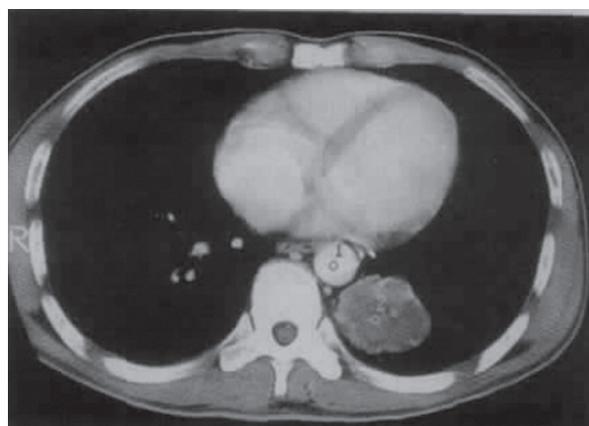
Dynamic contrast enhanced CT scan of left lower mucinous adenocarcinoma.
